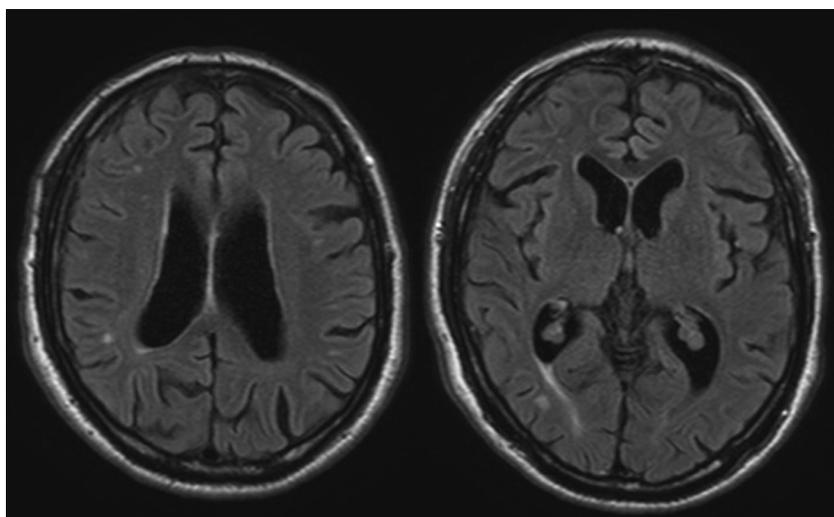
MRI obtained 6 hours after seizure onset. Fluid-attenuated inversion recovery (FLAIR) image at the level of the body of the lateral ventricle shows sulcal hyperintensity at the convexity underlying the hematoma (A), but the FLAIR image at the level of the anterior horn of the lateral ventricle shows no sulcal hyperintensity (B). T1-, T2-, T2\*-, and diffusion-weighted imaging revealed no abnormal findings in the brain parenchyma (C-F).
